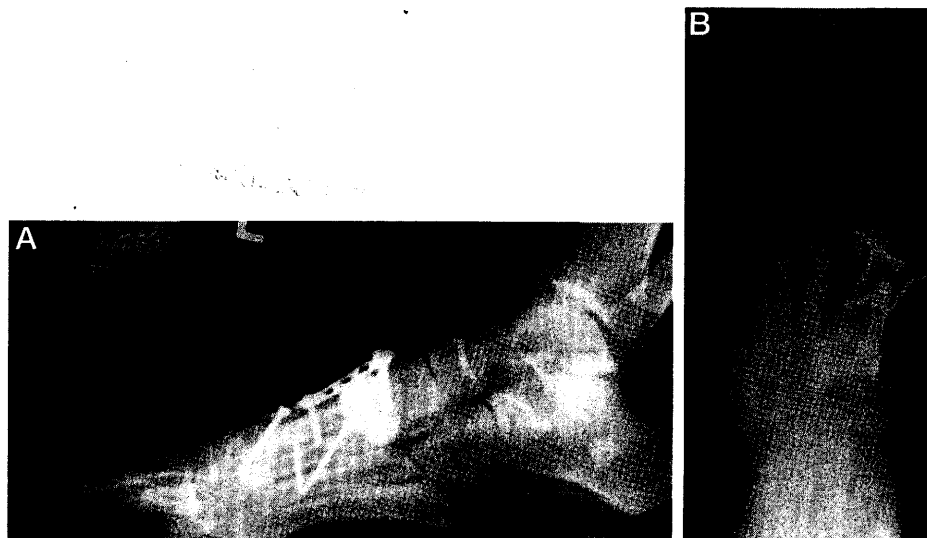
A, Lateral radiograph of left foot 11 weeks postoperative. Note placement of cortical allograft into fusion site and capital osteotomy, which is transposed plantarly to gain further correction. Also note the cortical window in calcaneus where cancellous autograft was retrieved. A 0.062-inch K-wire is placed obliquely to aid in stabilizing the graft in conjunction with the one-third tubular plate. B, Anterior-posterior radiograph of left foot 11 weeks postoperatively. Fixation with the one-third tubular plate is used to maintain position while graft is incorporated. 0.062-inch K-wire is placed obliquely to maintain the stability of the lateral aspect of fusion site.
